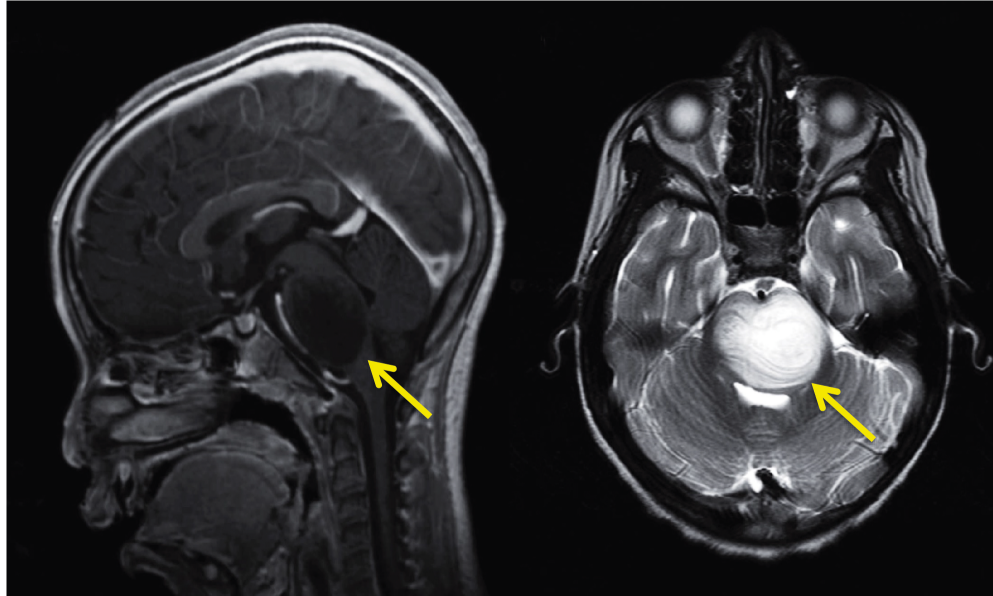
MRI images of paediatric patient with DIPG. Sagittal and axial T2 weighted MRI images demonstrating an expansile lesion located in the pons consistent with a radiological diagnosis of DIPG (yellow arrow). Images provided by Lynley Marshall.
